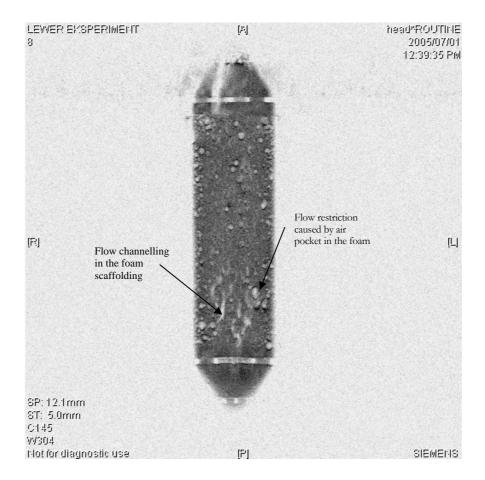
MRI imagining, flow channelling in the scaffolding
